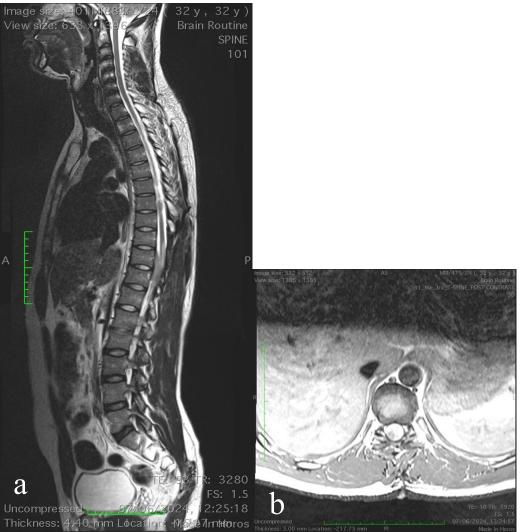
(a) Sagittal whole spine T2W MRI showing T10 spinal mass with compression of the spinal cord, with evidence of previous laminectomy (d) Axial T1W post gadolinium MRI of the spine showing contrast enhanced intradural extramedullary mass at T10, compressing the spinal cord in a concentric orientation
